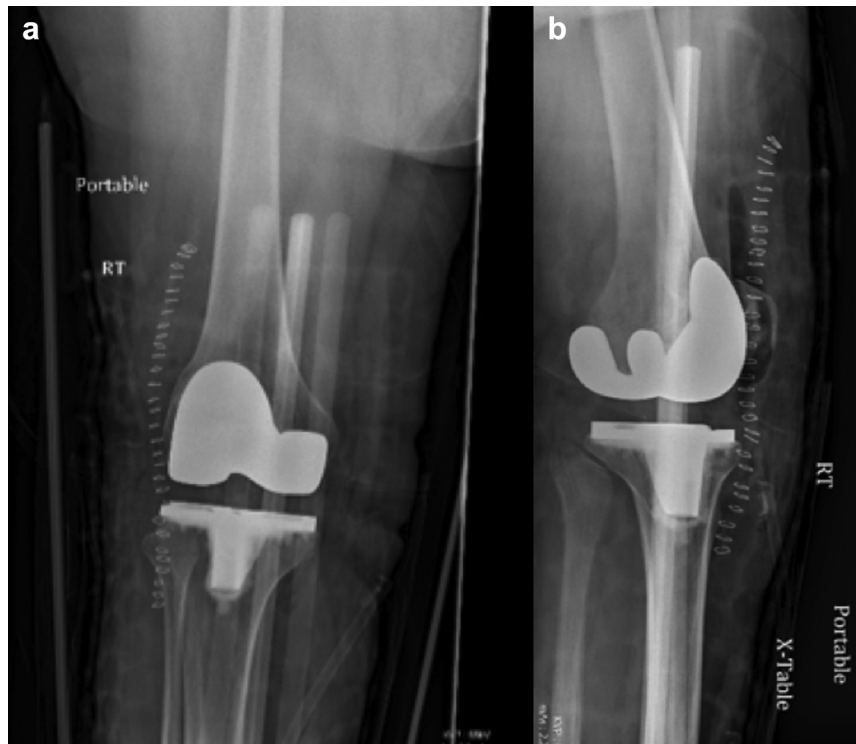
Postoperative (a) anteroposterior and (b) lateral radiographs of the patient. Prosthesis appears in correct position with no radiographic evidence of hardware complication.
